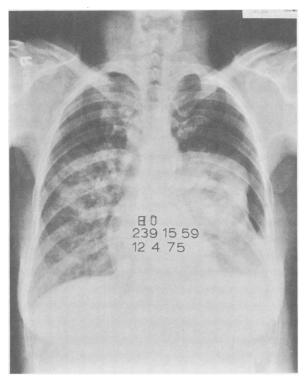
Posteroanterior chest roentgenogram showing diffuse reticular, linear and nodular infiltration in both lungs with pneumothorax on the left. Note the rarifaction in the center of the collapsed lung.
